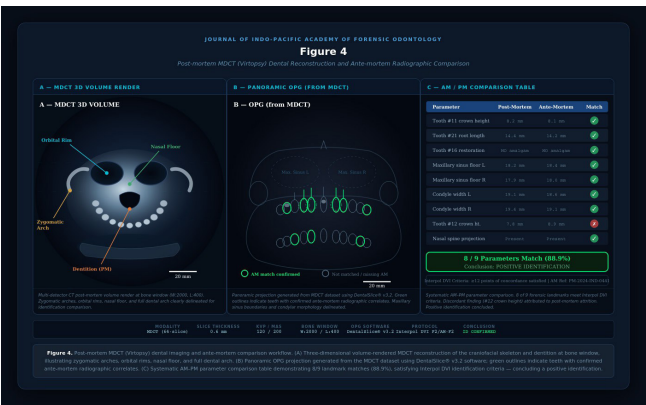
Post-mortem MDCT (Virtopsy) dental reconstruction (A) Volume-rendered 3D view of dentition, (B) Corresponding orthopantomograph projection generated from CT data, (C) Overlay comparison with ante-mortem panoramic radiograph for identification.
